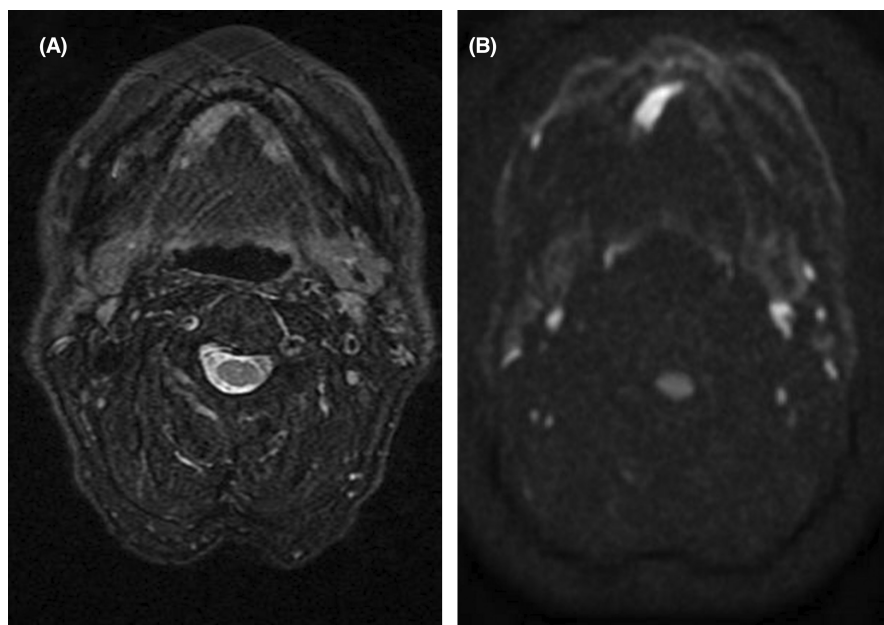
Preoperative images. Mass lesion detection in the right sublingual gland on MRI. The lesion shows higher intensity on T2-weighted imaging (A) and STIR (B) in comparison with that in the left sublingual gland
